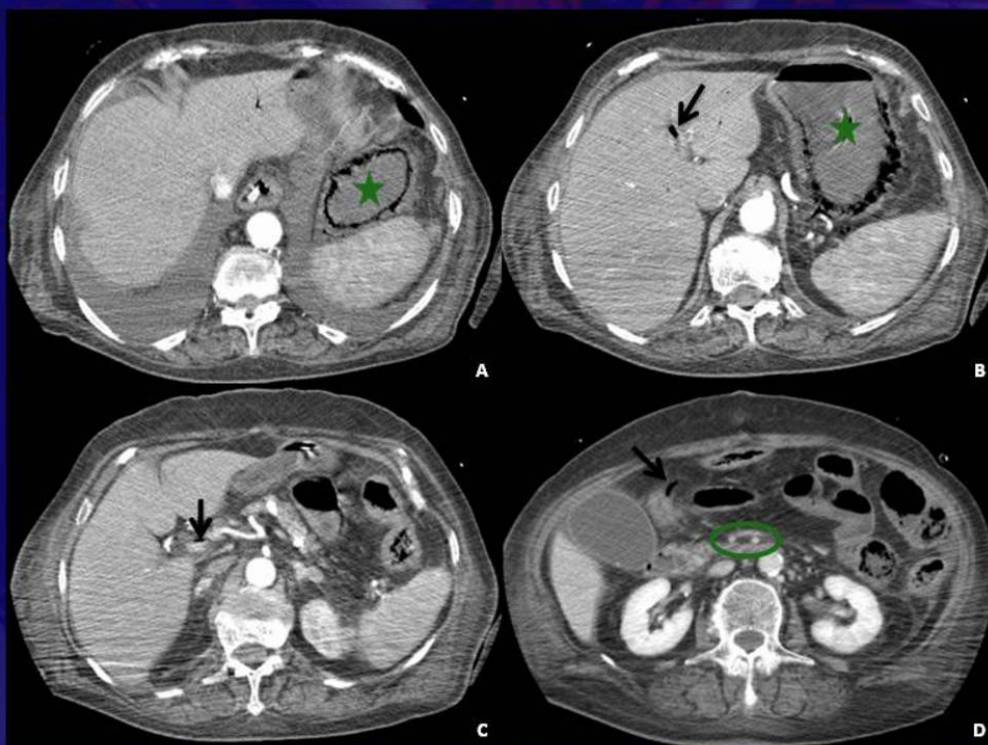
Non-occlusive mesenteric ischemia (NOMI). Acute ischemia due to hypoperfusion. a) and b) Contrast-enhanced CT images demonstrate gastric wall pneumatosis (star); arrows on (B), (C) and (D) indicate respectively gas in the intra-hepatic portal vein, in the portal main trunk and in a mesenteric vessel; there is patency of both the SMA and the SMV (circle on (D)).
